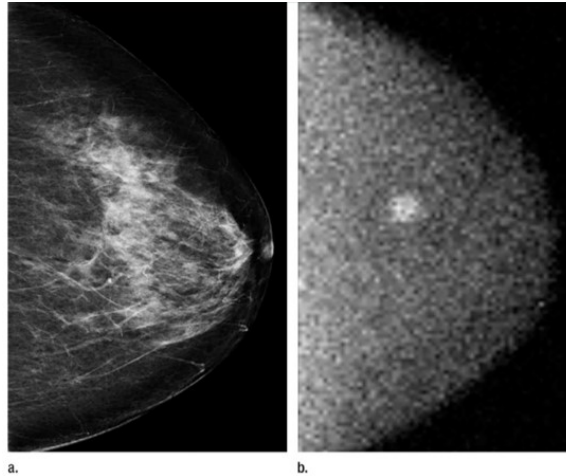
Direct comparison of the same breast imaged using a) standard x-ray mammography and b) MBI. The location of the breast tumor is clearly seen in using MBI, while there is some uncertainty associated with the mammogram. Images reproduced from Rhodes et al. (2011).
